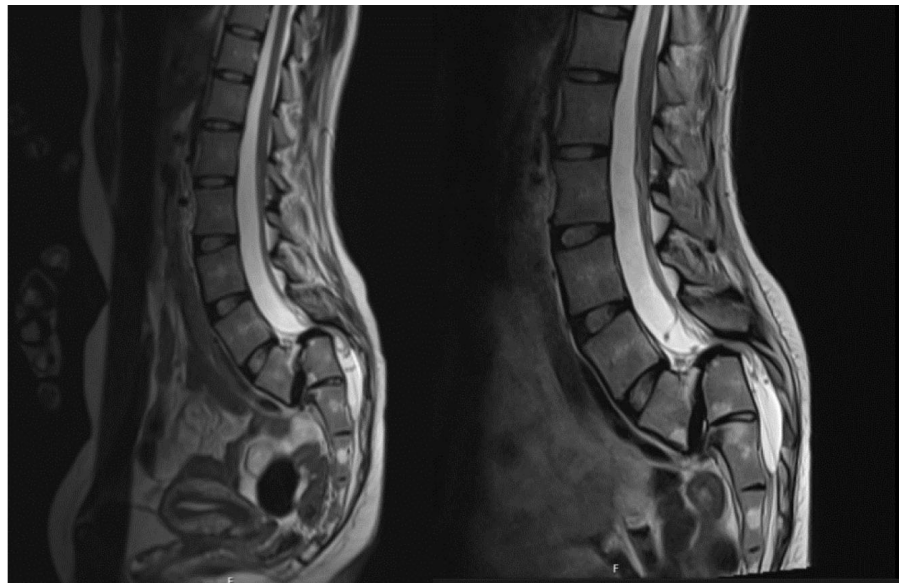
Pre-operative sagittal MRI.
